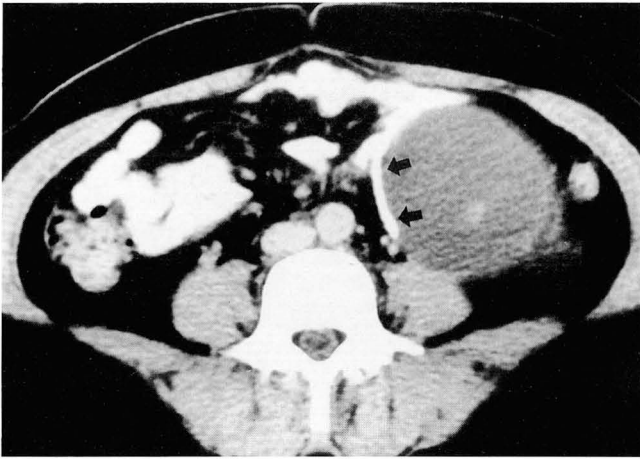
On contrast enhanced abdominal computed tomography, a round homogeneous hypoattenuated cystic mass with marginal calcification (arrows) is noted on the lower pole of left kidney.
